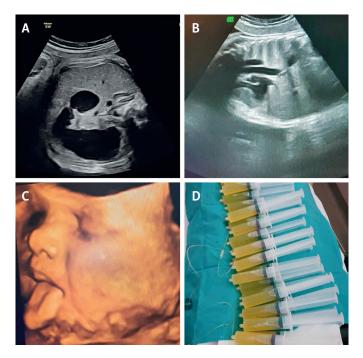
A: Double bubble sign at ultrasound that indicated duodenal atresia; B: Oesophageal dilatation; C: The fetus regurgitates water, D: Amnioreduction of 1700 ml of amniotic fluid.
